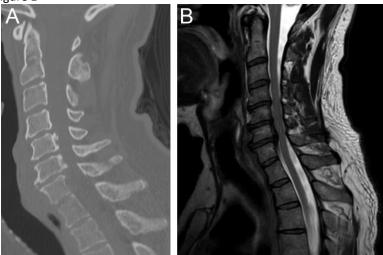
Preoperative sagittal CT scan reveals ossification of the posterior longitudinal ligament at C5 and C6 (A). A sagittal T2 weighted MRI depicts severe spinal stenosis from C4-C7 with T2 signal changes of the spinal cord (B).
